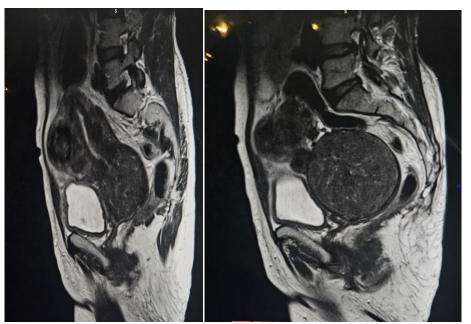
MRI Showing Large exophytic intramural fibroid 7.0 x 7.1 x 7.6 cms is seen in right lateral lower myometrial wall and cervix and multiple fibroids in the uterus
